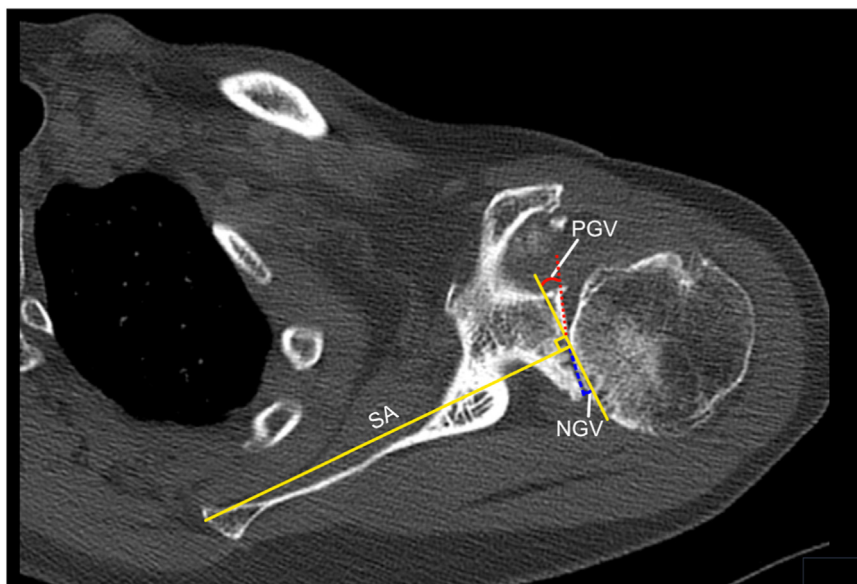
Axial CT measurements. SA, scapular axis; PGV, paleoglenoid version; NGV, neoglenoid version; CT, computed tomography.
